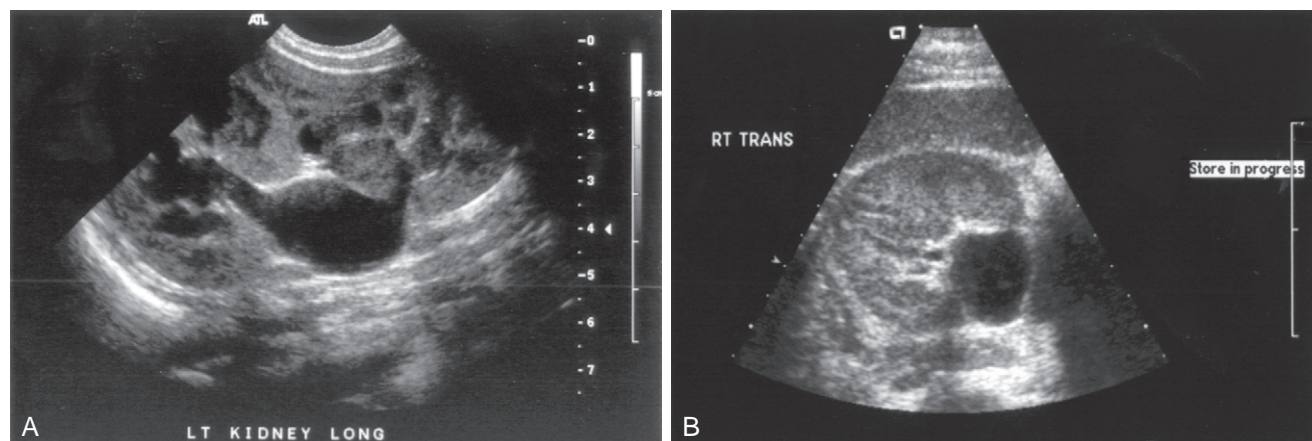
A, Renal ultrasound representing an obstructed ureteropelvic junction with an intrarenal pelvis. B, Renal ultrasound of a nonobstructed extrarenal pelvis. (Courtesy Children's Hospital and Regional Medical Center, Seattle.)
